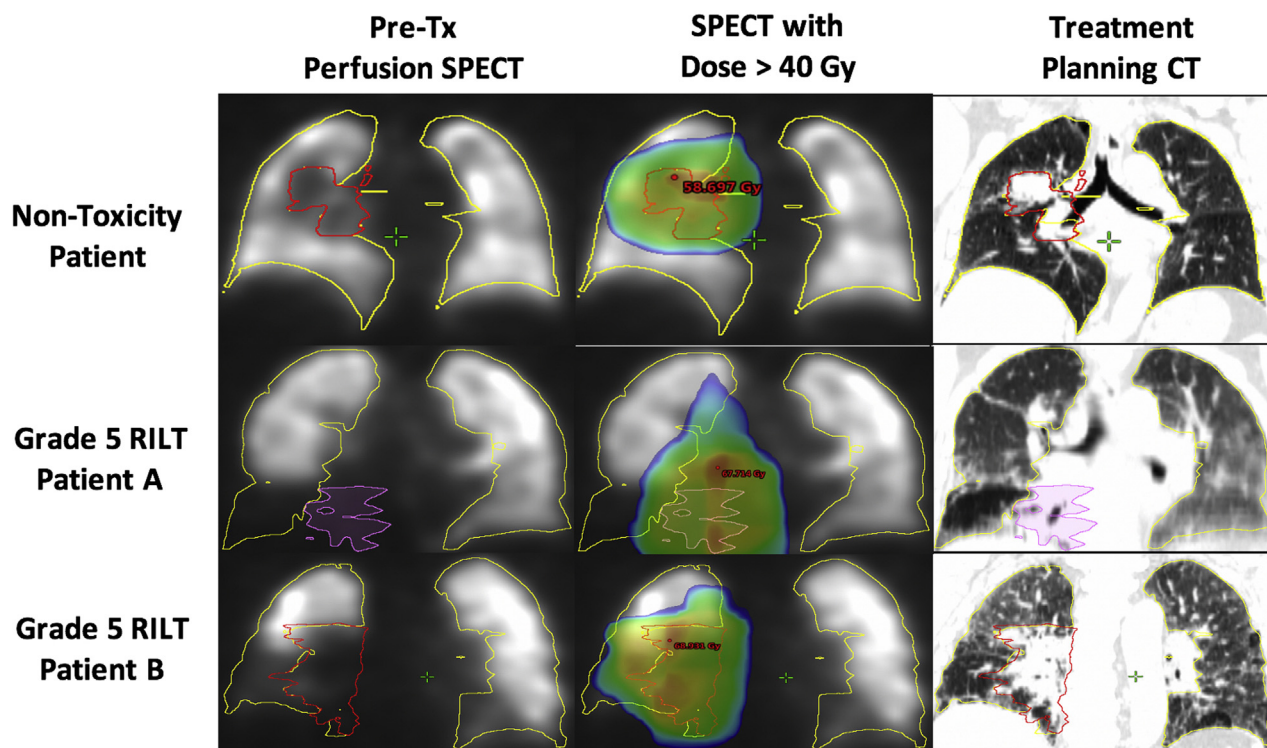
Pretreatment perfusion scans (left column), overlaid with dose >40 Gy (middle column), and the treatment planning computed tomography (right column) for a nontoxicity patient (top row), grade 5 Patient A (middle row), and grade 5 Patient B (bottom row).
